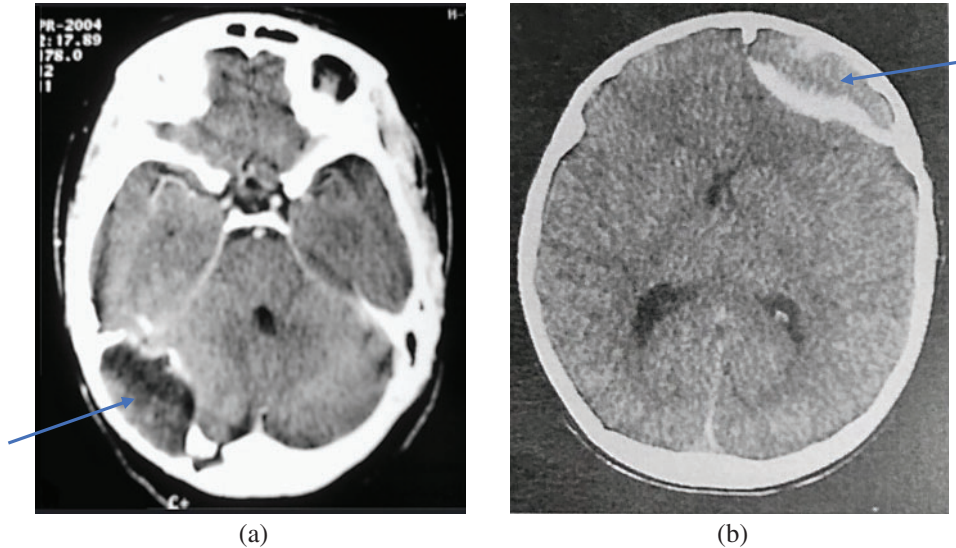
Brain CT axial sections showing (a) a heterogeneous cystic mass with hypo and left frontal hematoma extra dural in the hyperdense areas and (b) the lesion-destroying process of calcification (blue arrow). The left occipital bone (blue arrow).
